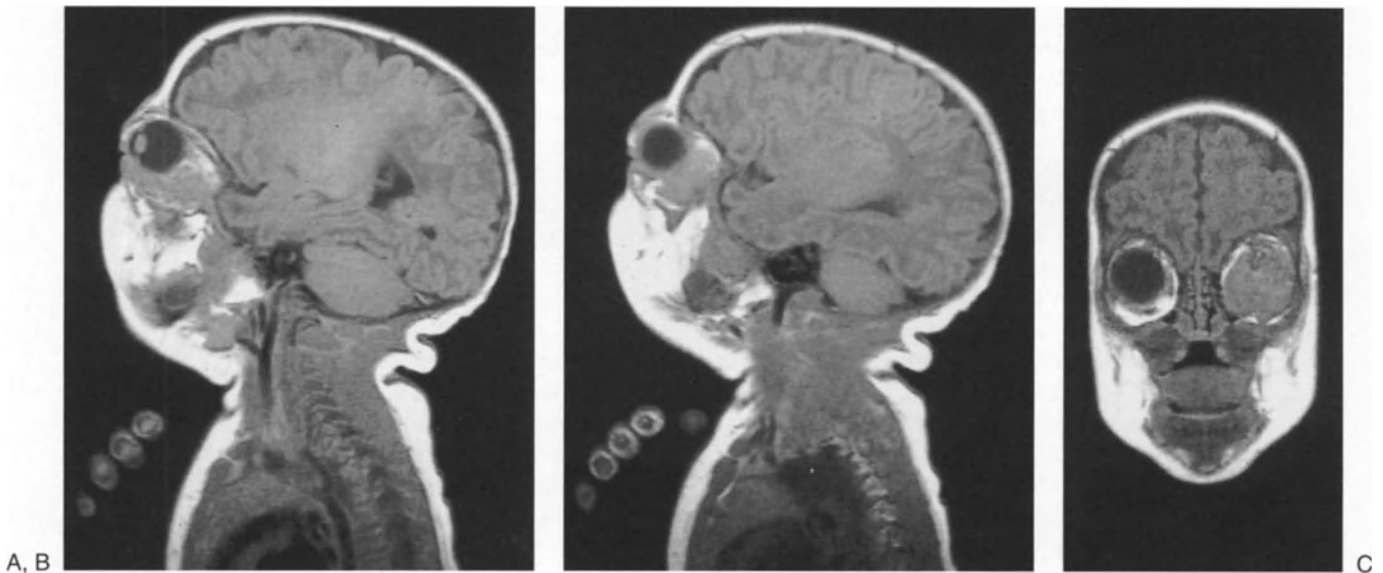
This figure is of particular value in that it provides adequate information to permit the surgeon, wishing to perform a biopsy, to plan the orbital approach. The child, 1 month old, has a *lymphangioma* of the left orbit which progressed steadily in volume, as determined by the exophthalmus. In (A) the tumor mass is revealed to occupy the inferior splanchnocranial portion of the orbit, displacing the globe superiorly and anteriorly. In (B), a more laterally placed MRI
